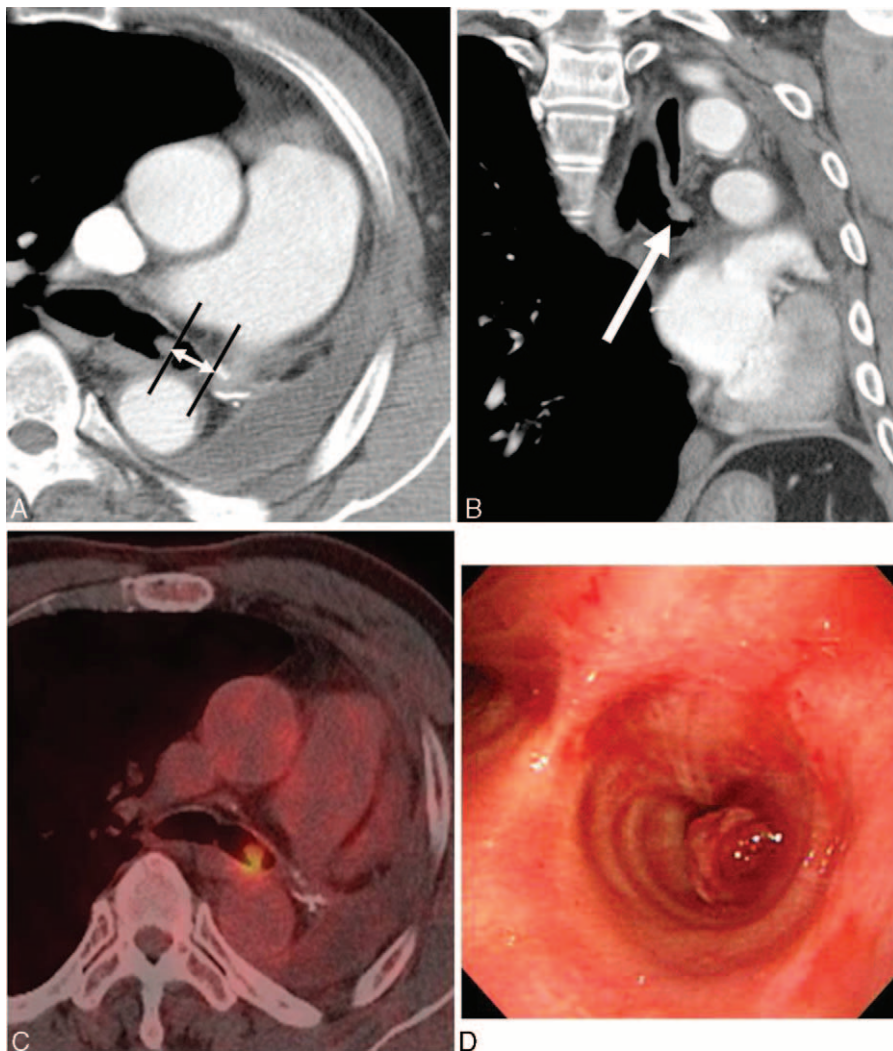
A 69-year-old man with tumor recurrence after left pneumonectomy for squamous cell lung cancer (pT1,N1,M0). A, Conventional CT transverse image with mediastinal window (3-mm thickness reconstruction) was obtained at the level of bilateral main stem bronchi. CT image shows round-to-oval shape enhancing endobronchial nodule with 9 mm in long diameter at the left main bronchus and with 20 mm distance from surgical staples (arrow). B, Coronal reformatted lung image (3-mm thickness reconstruction) was obtained at the level of left atrium. Note the nodule abutting the upper wall of the left main bronchus (arrow). C, On 18-FDG-PET, the maximum standardized uptake value of the nodule was 3.6. D, Photograph of bronchoscopy shows endobronchial polypoid nodule. Recurrent cancer was revealed on bronchoscopic biopsy.
